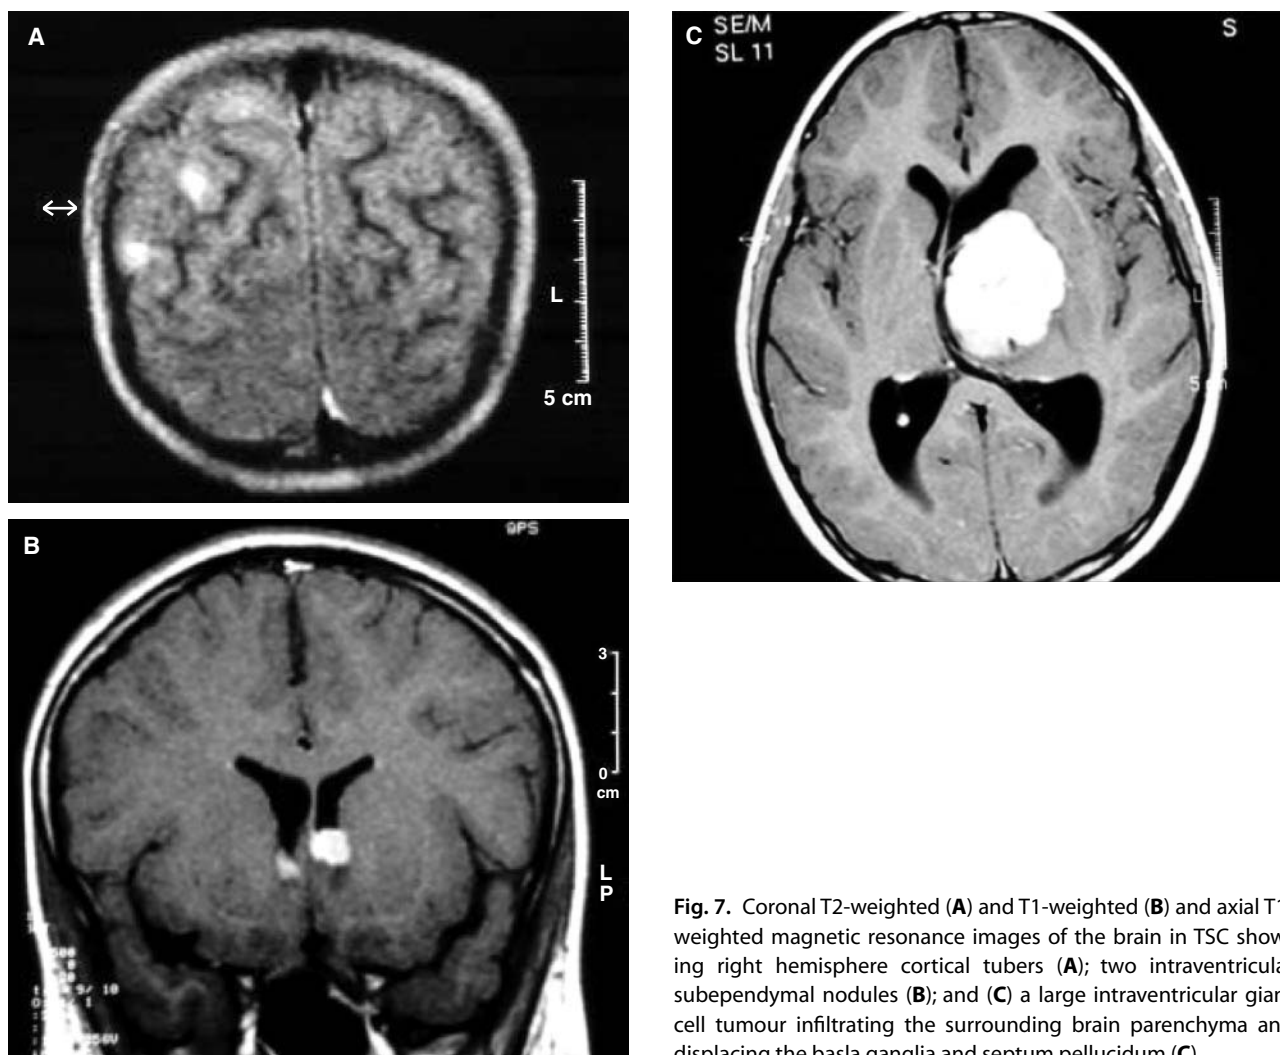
Coronal T2-weighted (A) and T1-weighted (B) and axial T1-weighted magnetic resonance images of the brain in TSC showing right hemisphere cortical tubers (A); two intraventricular subependymal nodules (B); and (C) a large intraventricular giant cell tumour infiltrating the surrounding brain parenchyma and displacing the basla ganglia and septum pellucidum (C).
